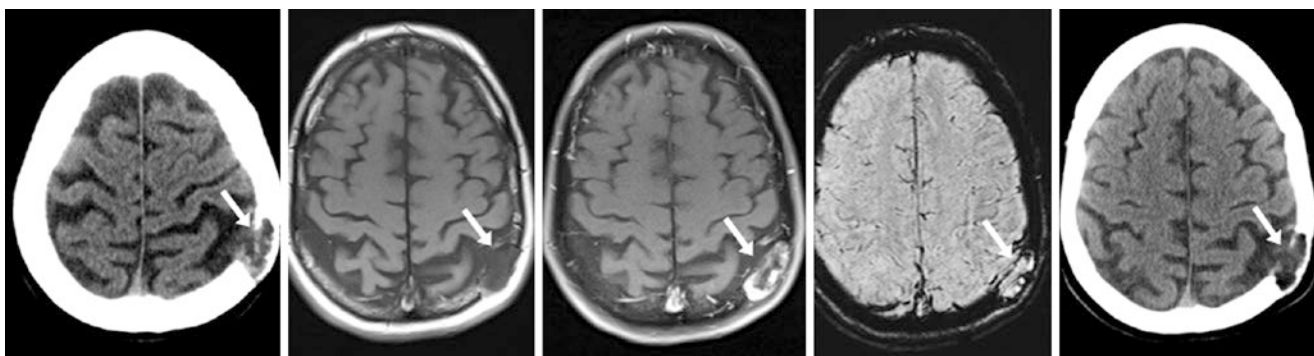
A 47 year old with a parietal lesion (*arrows*) on NECT (*left*) that was shown to be hypointense on noncontrast T1WI (*left middle*), with peripheral enhancement after contrast (*middle*) on 1.5 T MRI; SWI (*right middle*) and DWI (*not shown*) depicted that it was mostly bright, likely due to T2-shine through effect. This was unchanged 3 years later on CT (*right*)
